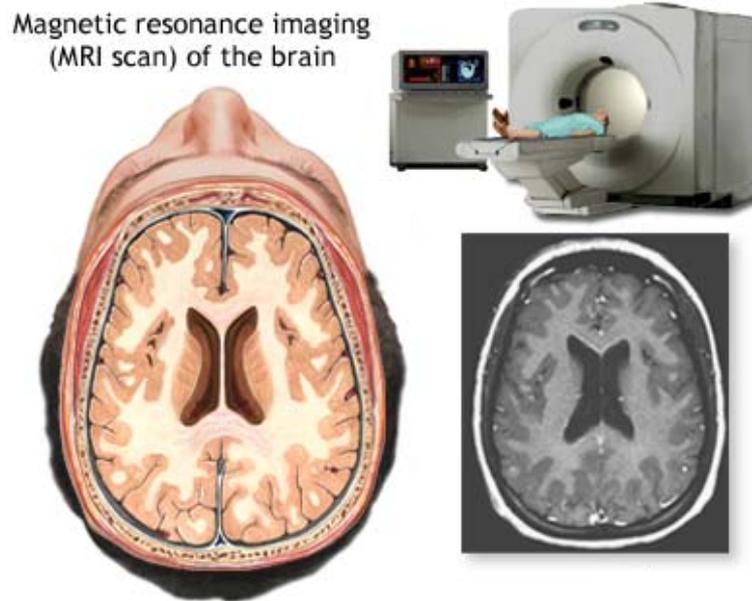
An MRI (Magnetic resonance imaging) of the brain [3]
